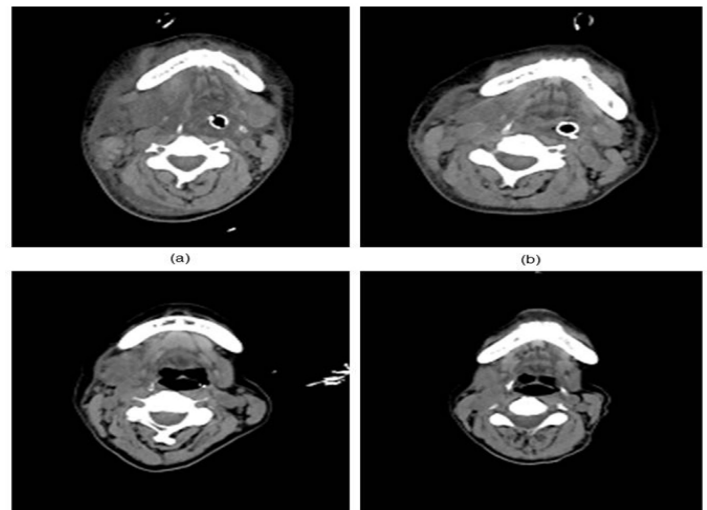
Case 2. Computed tomography images at the level of the superior border of the hyoid bone: (a) The intraoral cavity filled with soft tissue swelling and compressed by right submandibular gland swelling on postoperative day 1, (b) progressive swelling of the soft tissue and right submandibular gland in the oral cavity on day 7, (c) remaining submandibular gland swelling on day 20, and (d) swelling almost completely resolved on day 45.
